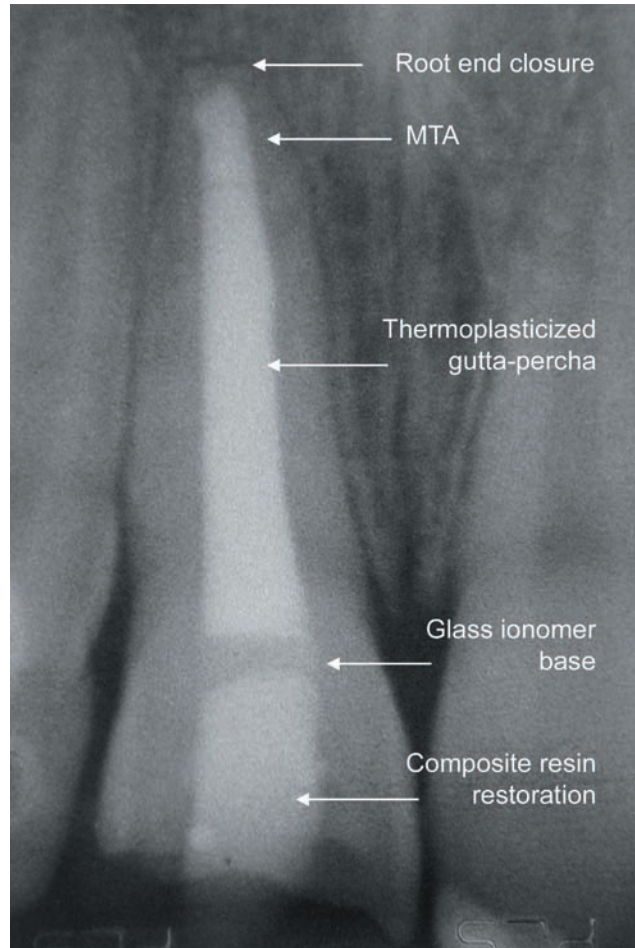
One-year post-MTA apexification radiograph showing complete closure of root
